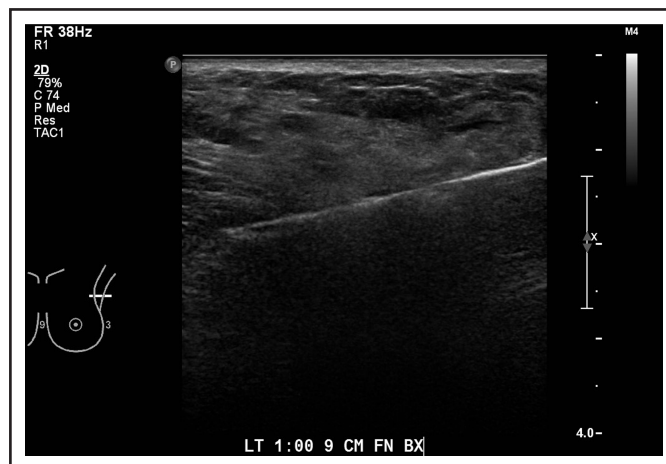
Ultrasound. Ultrasound-guided core-needle biopsy of the mass.
